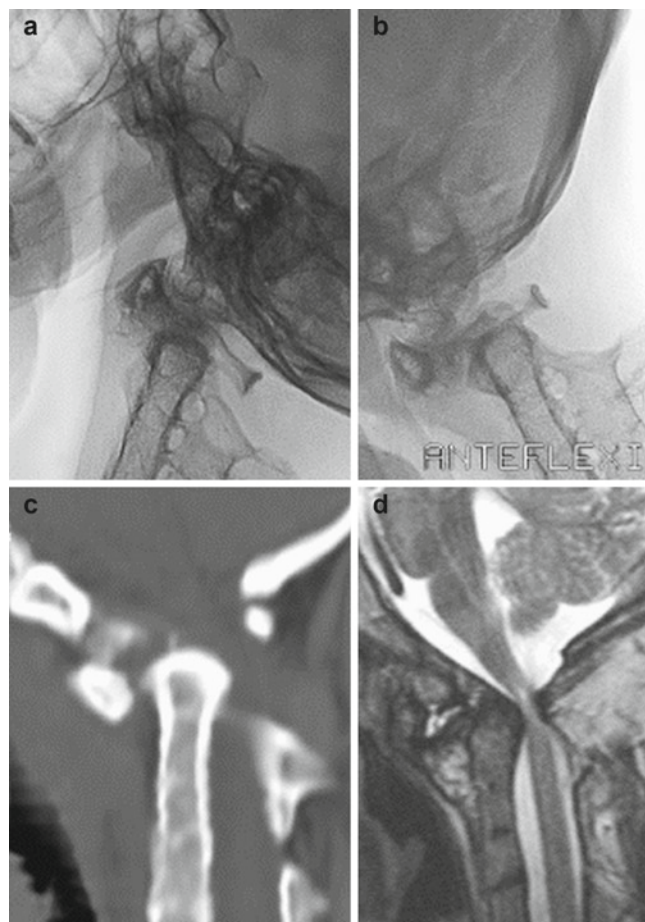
Craniocervical dysplasia. Plain radiograph in backward (a) and forward tilt (b) CT in sagittal reconstruction (c) T2-weighted MRI (d) shortening of the clivus, separate disposition of the dens process as odontoid bone with pseudoarthrosis and anterolisthesis (including atlas and occiput) vis-à-vis the dens, resulting in severe stenosis between the upwardly displaced posterior arch of the atlas and the posterior border of the second cervical vertebral body and dens with malacia (bright signal on T2-weighting) in the caudal part of the medulla oblongata. Only slight increase in forward slippage on forward tilt (comp. a and b). Synostosis C2–5
